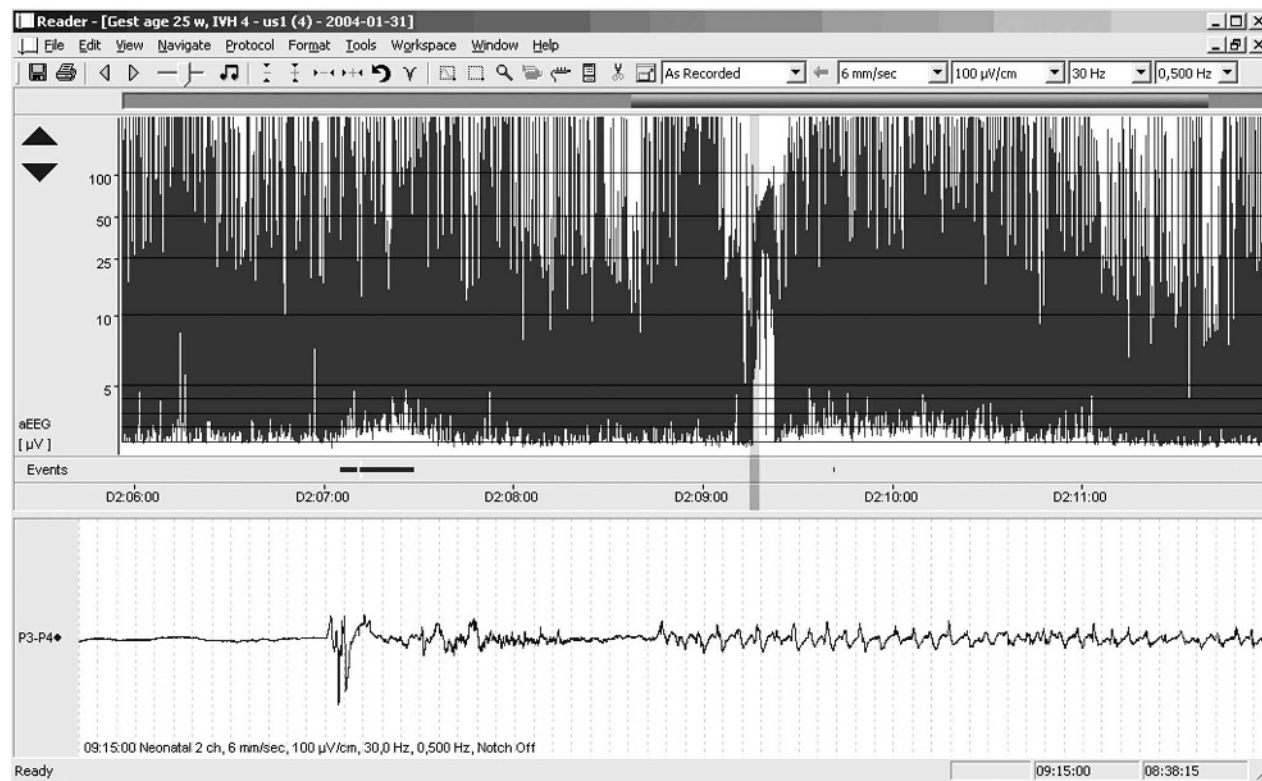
Preterm infant, born at 25 weeks gestation with intraventricular haemorrhage grade 4 on ultrasound. The infant is mechanically ventilated and sedated with a continuous infusion of morphine. The amplitude integrated electroencephalographic (aEEG) recording has a duration of six hours and shows discontinuous background activity (burst suppression) without cyclical changes. A short seizure develops after 3.5 hours of recording, and can be seen in the aEEG as an abrupt and transient rise in the lower level of the trace. Below is 60 seconds of the raw EEG at the start of the seizure, corresponding to the shaded vertical line in the aEEG (NicoletOne; Vyasis).
